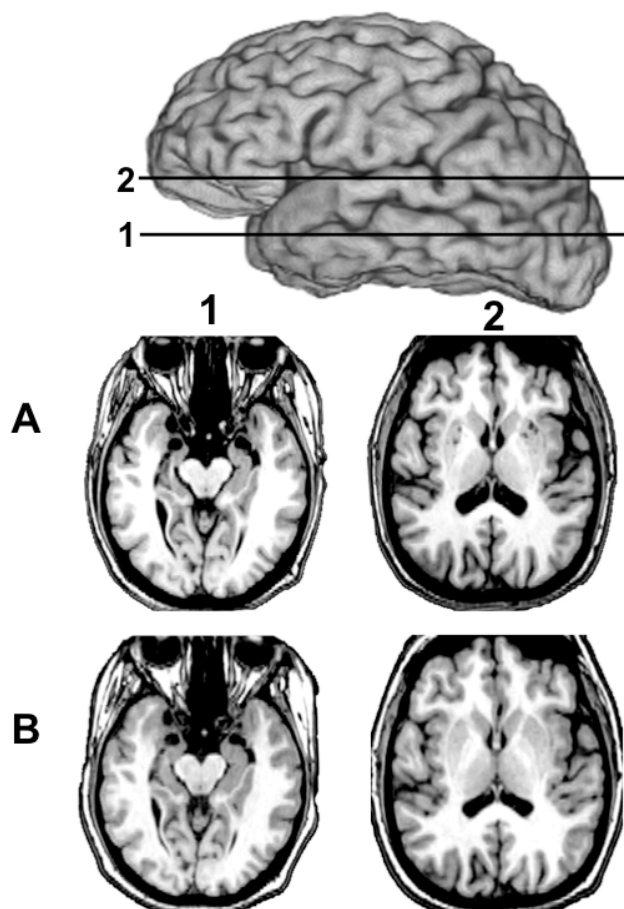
Structural MRI of SM's Brain
